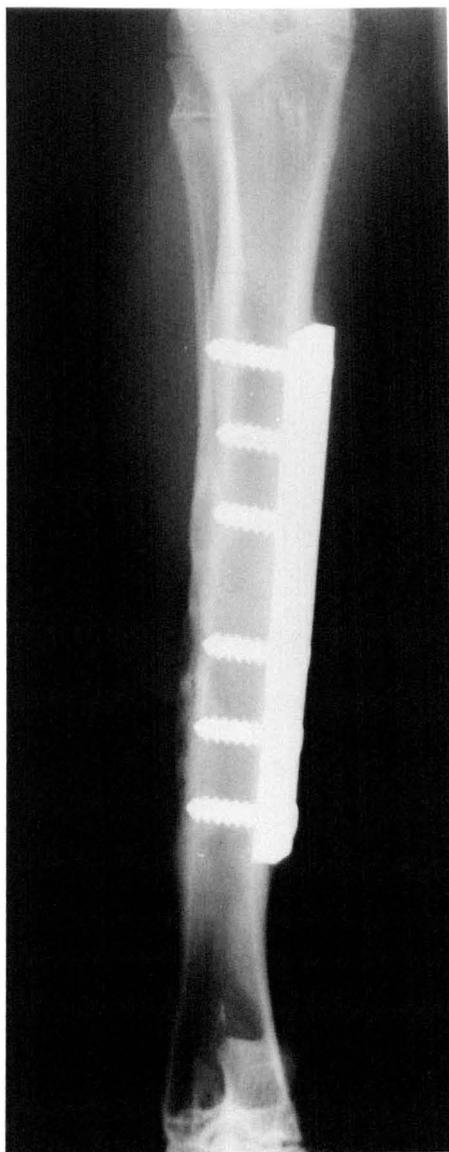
A radiograph obtained four weeks after fixation with a dynamic compression plate. There is periosteal reaction where the screws have pierced the lateral cortex.
